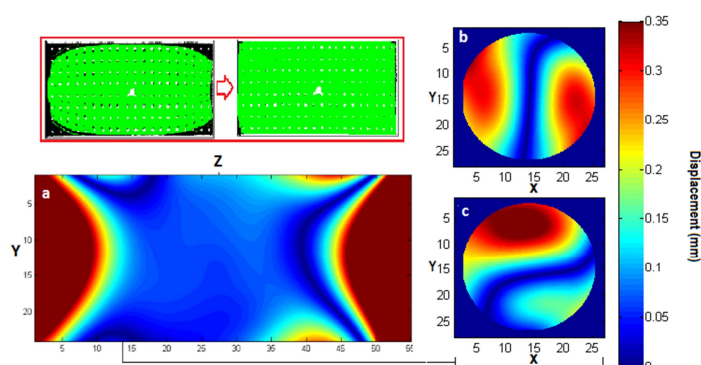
Displacement fields generated by the post processing correction in the z (a), x (b), and y (c) directions. Insert show CT and MRI alignment before and after registration
